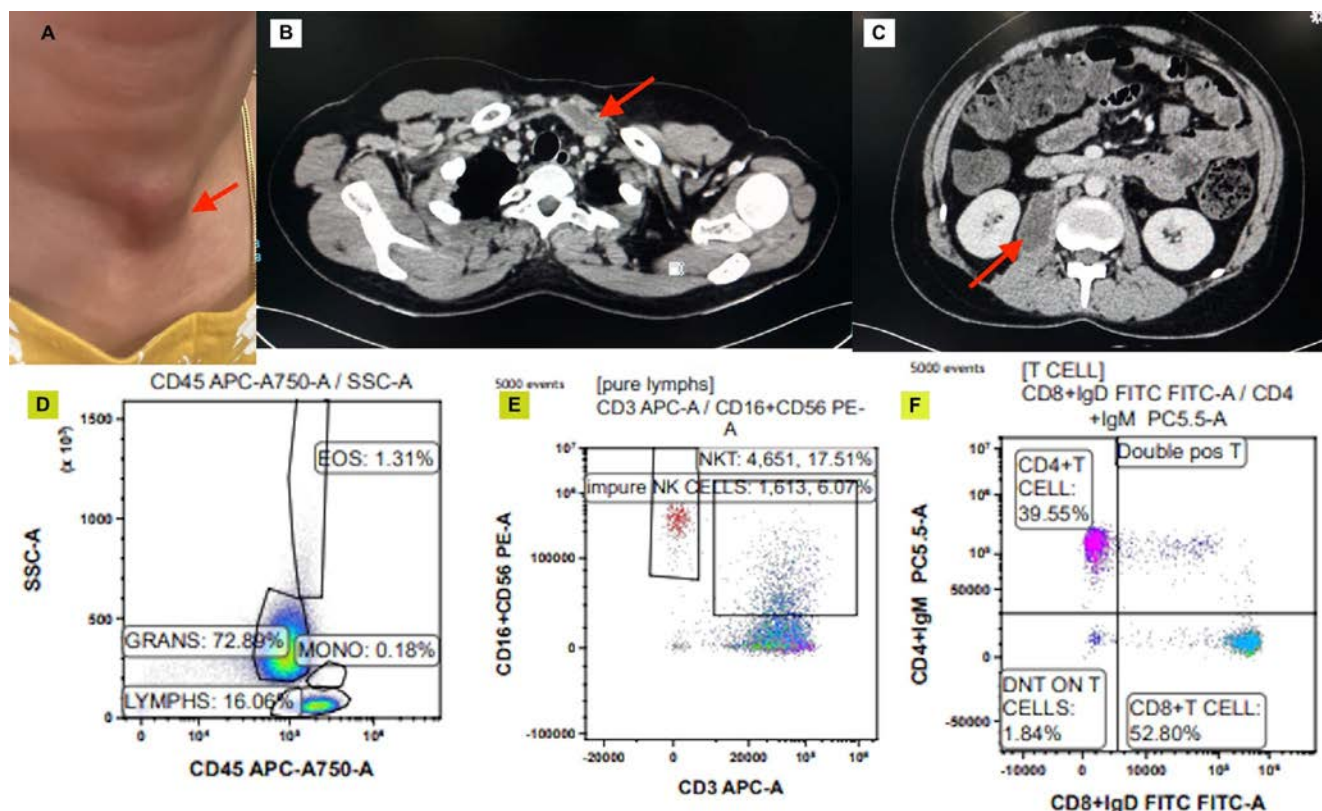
(A) Fluctuant swelling in front of the neck. (B) Axial contrast-enhanced CT scan at the level of the lower neck in the infrathyroid region shows a well-defined peripherally enhancing collection within the strap muscles on the left side. (C) Axial contrast-enhanced CT scan of the abdomen at the level of the upper pole of both kidneys shows a well-defined peripherally enhancing collection in the right psoas muscle. (D) Flow cytometry dot plots showing decreased lymphocytes and monocytes. (E) Flow cytometry dot plots showing decreased NK cells. (F) Flow cytometry dot plots showing decreased CD4 and CD8 T cells.
